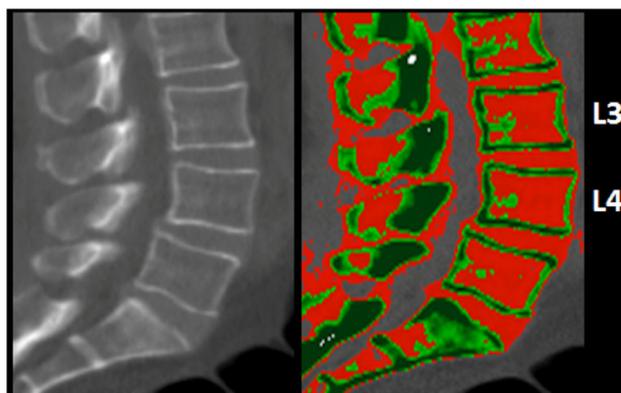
61-year-old female with low bone density (102 mg/cm³) per QCT. Post-processed CT of the central aspect of the spine are displayed in grayscale and color, with red color in the anterior two-thirds of the trabecular portion of the L3/L4 vertebral bodies, indicating low bone density.
